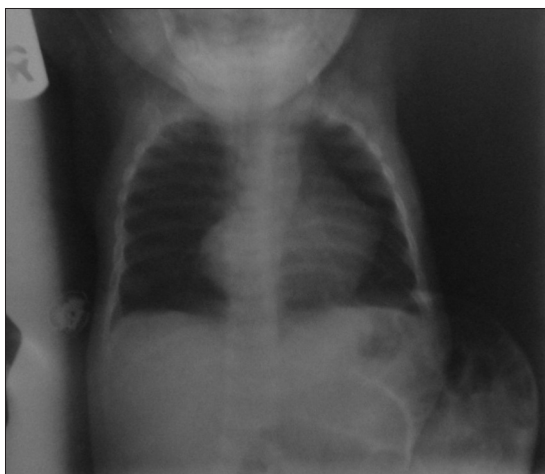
X-ray showing loops of bowel in the swelling with displacement of cardiac shadow
